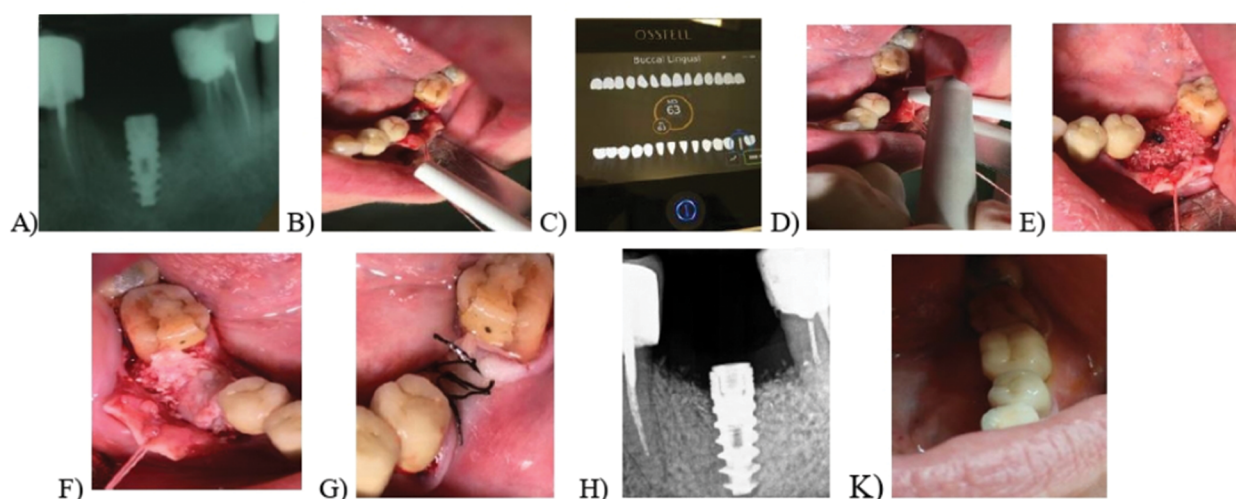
A) Intraoral X-ray of the implant in the area of 36; B) preparation of the flap; C) measured the implant's stability; D) Granulation tissue ablation and bone remodeling with Er-YAG laser; E) Filling the bone defect with ATB graft material; F) Coating the graft material with PRF membrane; G) adaptation and suturing of the mucoperiosteal flap; H) control radiography after three months; K) Prosthetic rehabilitation of the implant.
